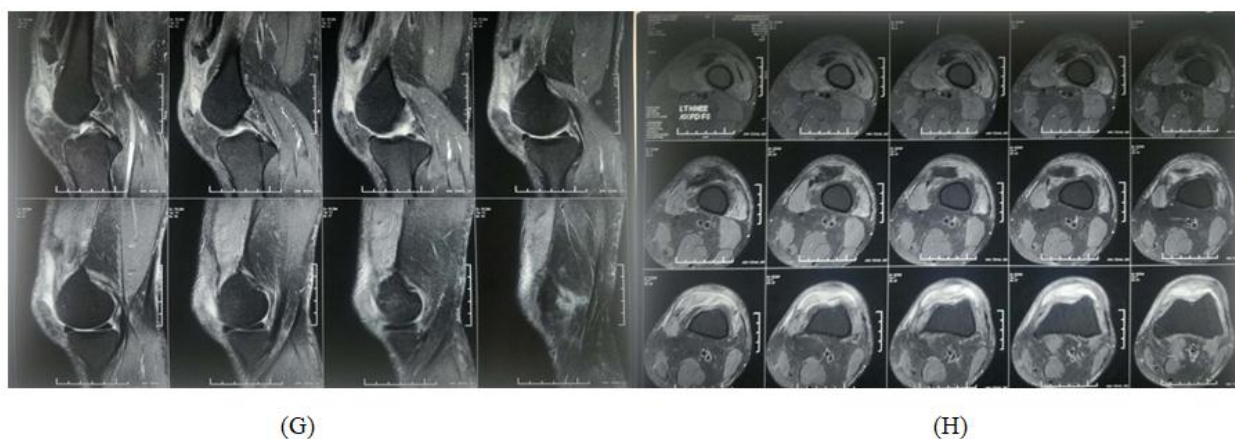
Preoperative MRI: Saggital view and axial view showing Post-traumatic superior patellar pole avulsion with tear in anterior fibres of quadriceps tendon.
